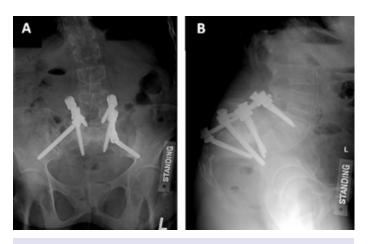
(a) Anter-oposterior and (b) lateral radiographs of the lumbar spinal stenosis showing the revision low back surgery with the extension of posterior instrumentation and fusion to the pelvis.
